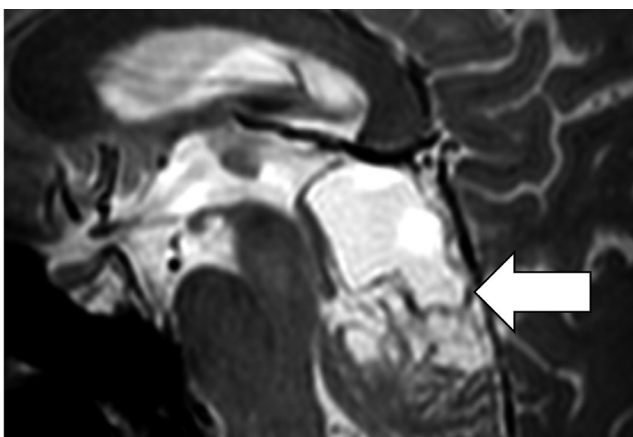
Sagittal T2-weighted magnetic resonance imaging revealed a multi-cystic mass lesion (arrow) located superior part of the vermis and extending to the quadrigeminal cistern. Mild-predominantly peripheral contrast enhancement was observed in the lesion on the post-contrast images (not shown).
